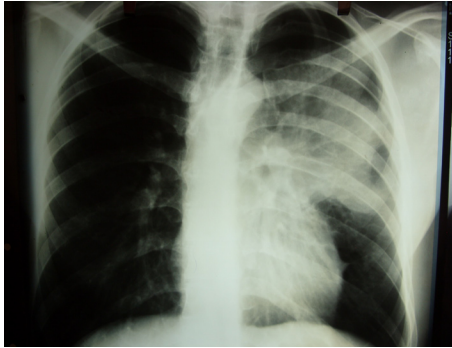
The P/A chest x-ray of the patient at the beginning of hospitalization.
